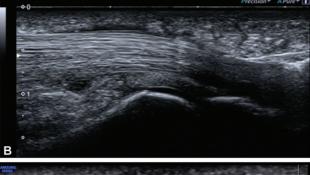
(A, B, C) Infiltration of trigger finger. In-plane infiltration of the third finger. Ultrasound (US) showing in-plane and out-of-plane trigger finger infiltration.
